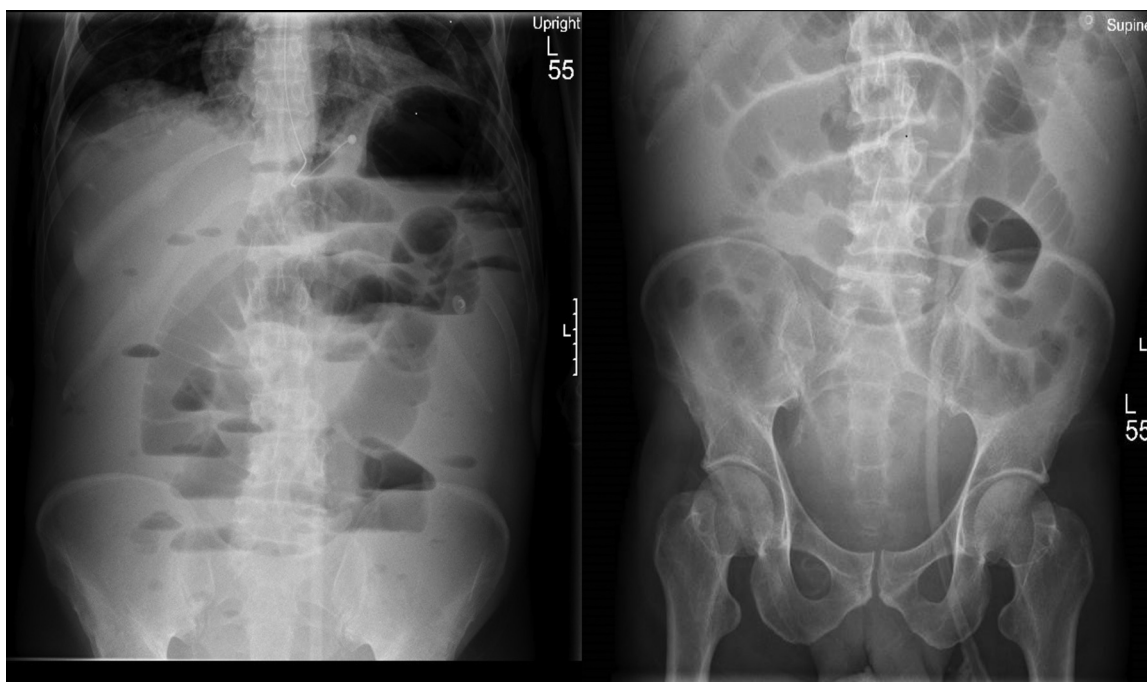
Plain X-ray abdomen showing dilated loops of small intestine, paucity of gas in distended colon loops and multiple air-fluid levels.
